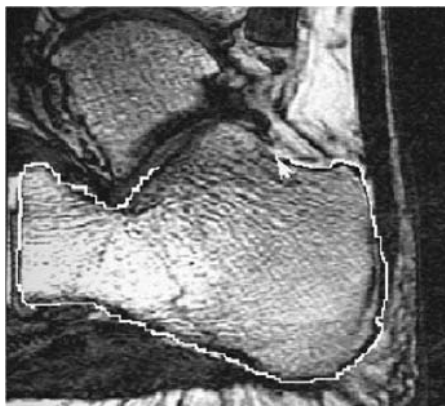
Segmented Magnetic Resonance Image Slice
